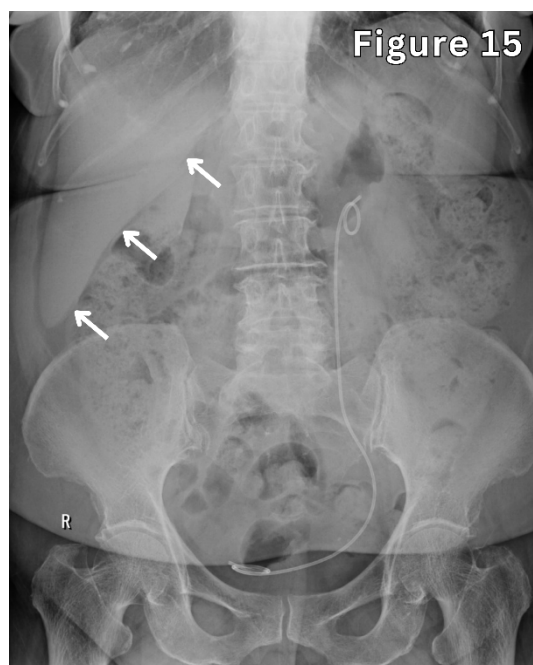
A 45-year-old female with urolithiasis. Abdominal X-ray shows an incidentally detected tongue-like inferior projection of the right lobe of the liver, suggestive of Riedel's lobe. *Note:* A left-sided ureteric stent is in situ.
